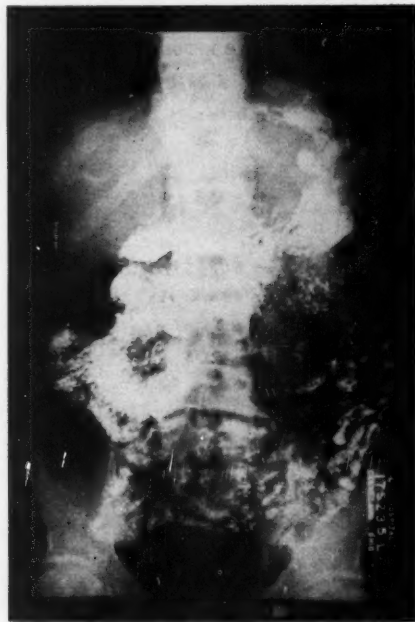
Radiograph made in Case 4 showing ulceration along lesser curvature above mid-portion.
